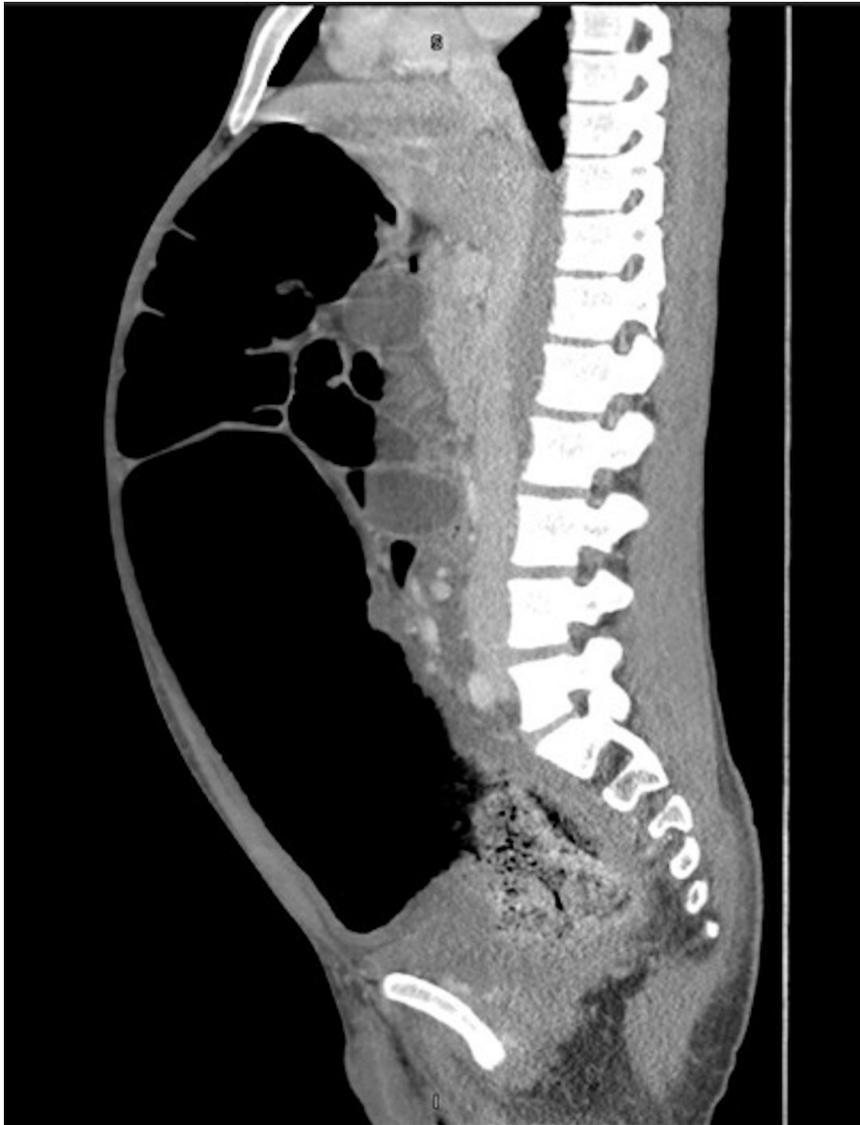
CT abdomen/pelvis with IV contrast sagittal view with colonic dilation and hard stool seen in the lumen of the large intestine.
